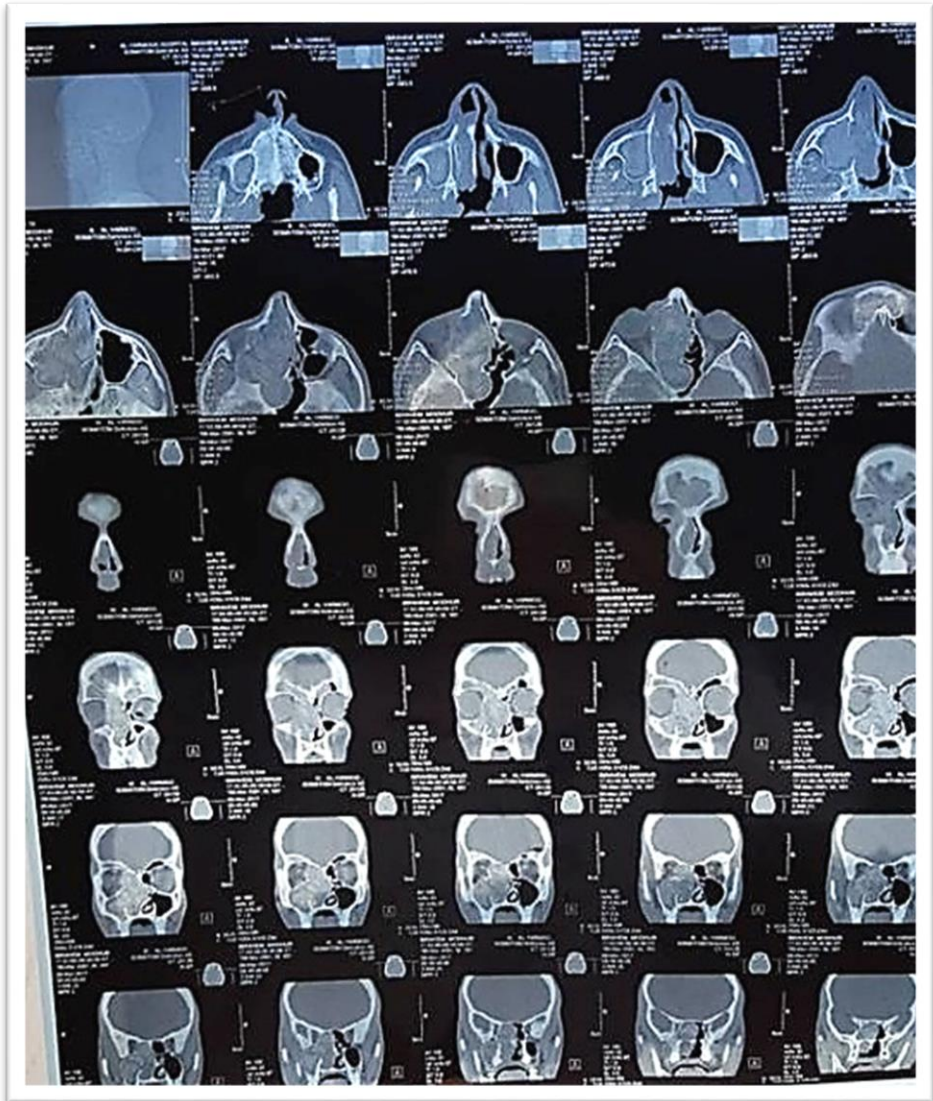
CT-scan of nose and paranasal sinuses (axial and coronal views) of one of our patients showing unilateral heterogeneous expanding opacity with bone erosion (Characteristic for AFRS) involving all the right sinuses in previously operated patient.
